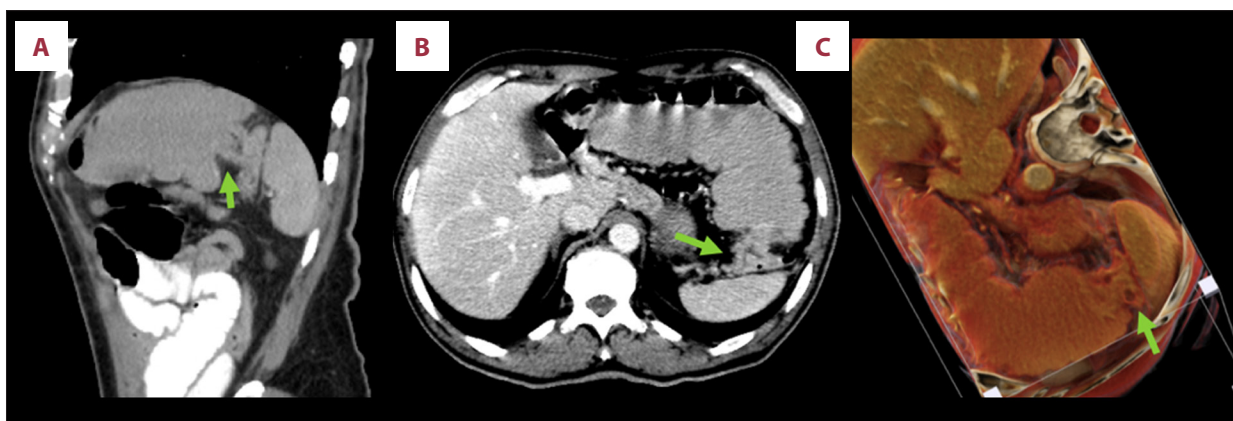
(A–C) Selected sagittal (A) and Axial (B) computed tomography scans of the upper abdomen with intravenous contrast in the portosystemic venous phase and oral contrast in our patient, who presented with suspected bowel obstruction. The images show focal circumferential narrowing of the descending colon at the splenic flexure, resulting in an “apple core” appearance that is pathognomonic for colonic adenocarcinoma (green arrow) and leads to high-grade bowel obstruction.
